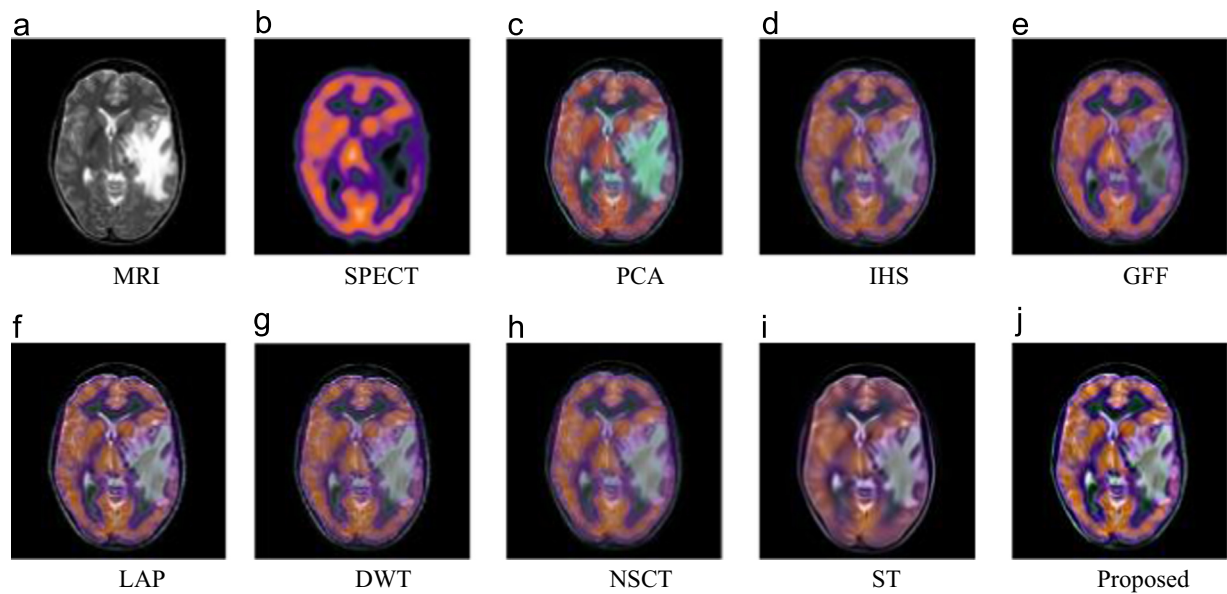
Example 2: Performance comparison of different methods on MRI-SPECT fusion.
